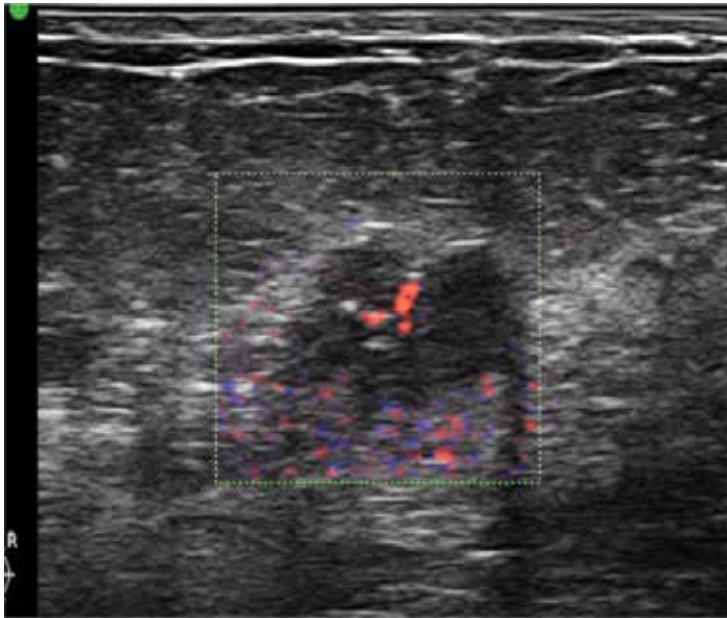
Carcinoma: not easy detectable. Suspicion was strengthened by color Doppler
